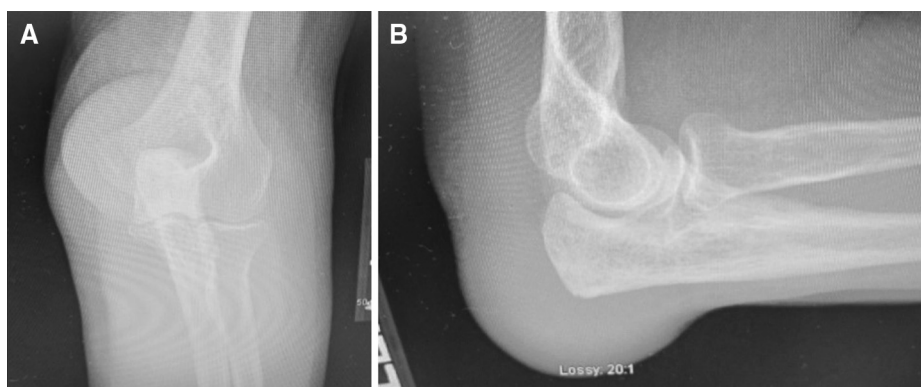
(A) Anteroposterior and (B) lateral radiographs of a patient with bursitis.
